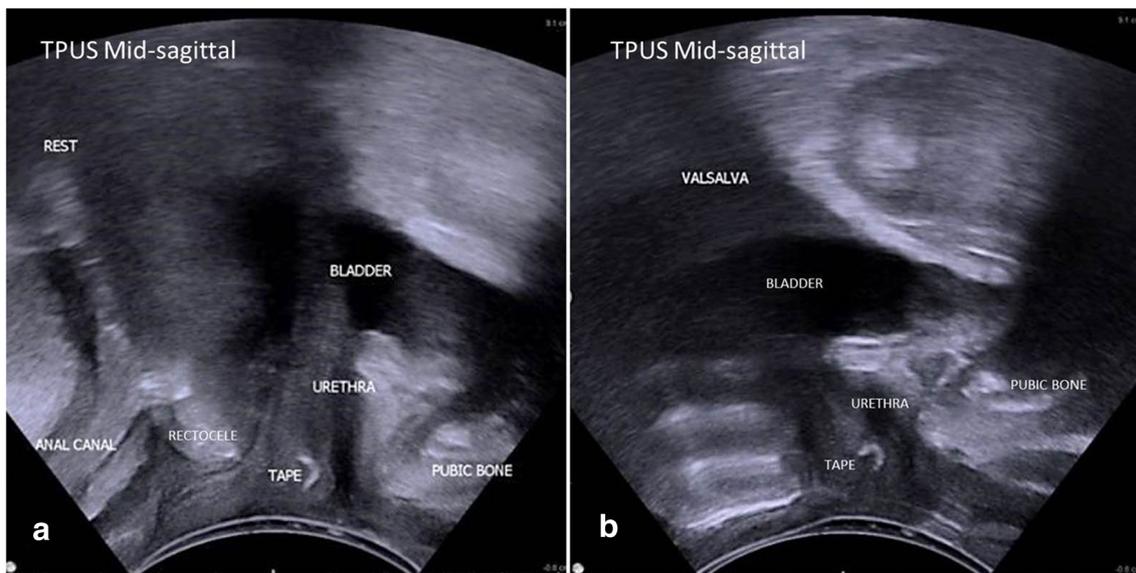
Shape of the mid-urethral sling (MUS). a Mid-sagittal view on perineal ultrasound showing the MUS labelled as tape as a “C” shape at rest. The patient has a rectocele at rest. b Mid-sagittal view on perineal ultrasound showing the MUS labelled as tape, which has folded into a
